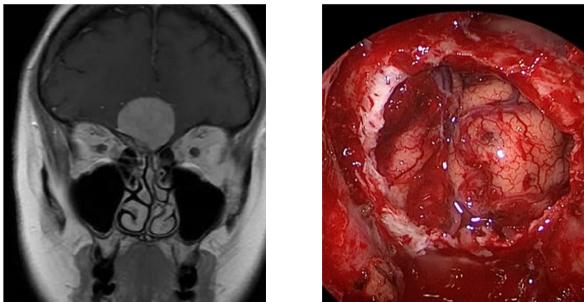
(Left) Coronal MRI T1 post contrast demonstrating 3cm OGM. (Right) Typical anterior cranial fossa defect following resection of bilateral olfactory groove meningioma.
